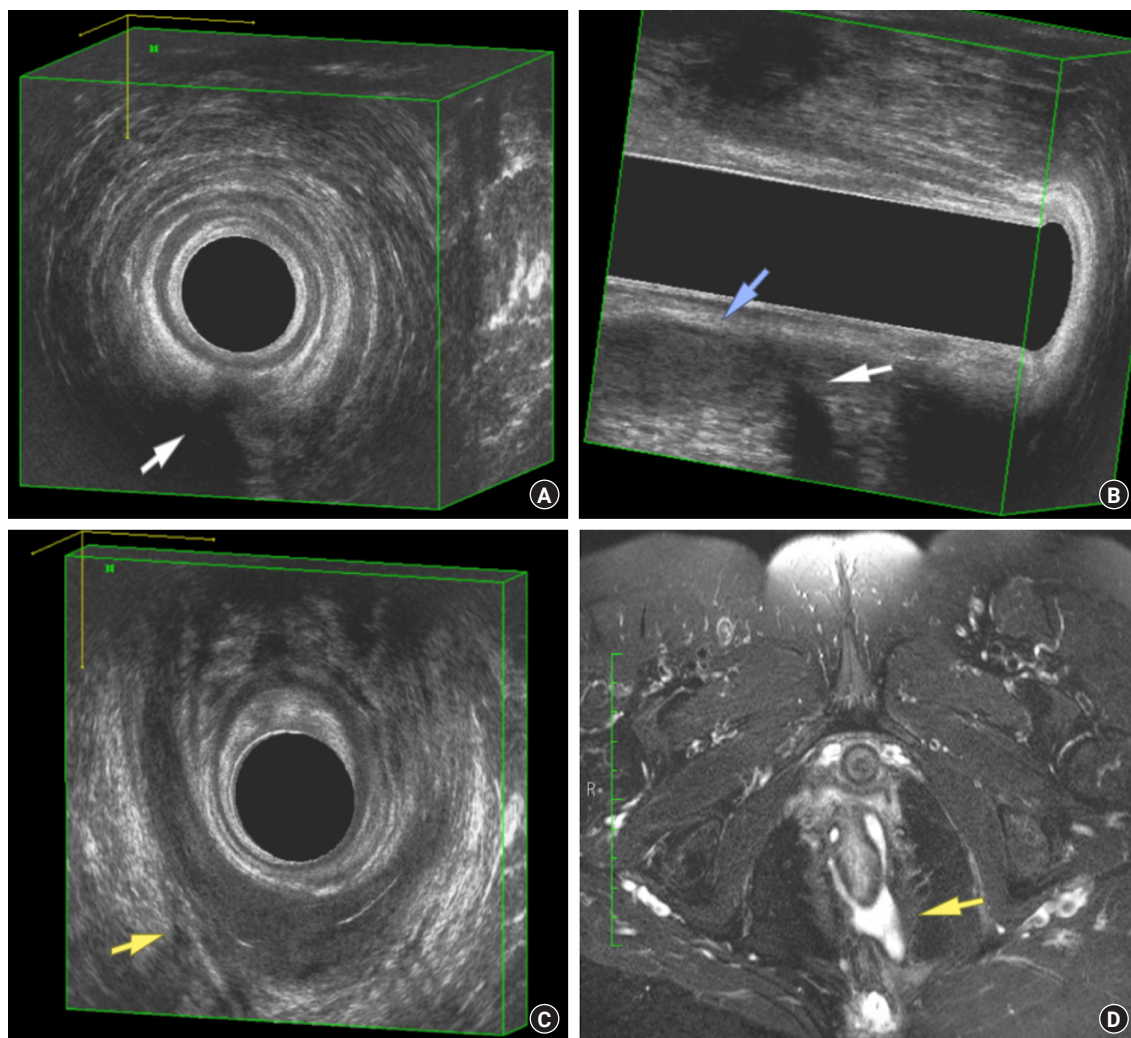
The imaging findings of a posterior transsphincteric fistula (white arrows) with a secondary tract extending via the intersphincteric route (blue arrow) into the supralevator space, forming a horseshoe abscess (yellow arrows). The 3-dimensional endoanal ultrasound images in (A) the axial plane and (B) the sagittal plane. (C) The axial 3-dimensional endoanal ultrasound image shows the posterior horseshoe abscess (yellow arrow) extending laterally in the supralevator space. (D) The magnetic resonance imaging T2-weighted fat-saturated high-resolution sequence in the axial plane. This fistula was categorized as grade 3C by the new classification.
